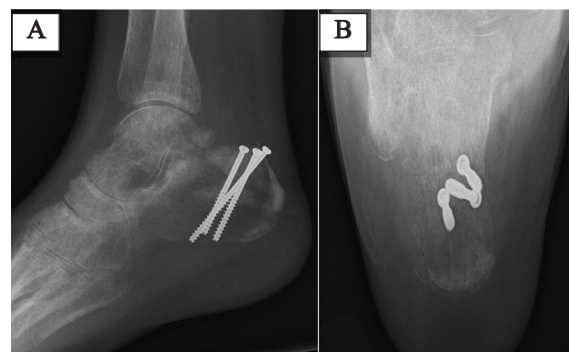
Radiographs at 14-week follow-up post-reoperation. (A) Lateral and (B) axial views of the calcaneus demonstrating maintained alignment, correct screw positioning, and signs of fracture healing.
